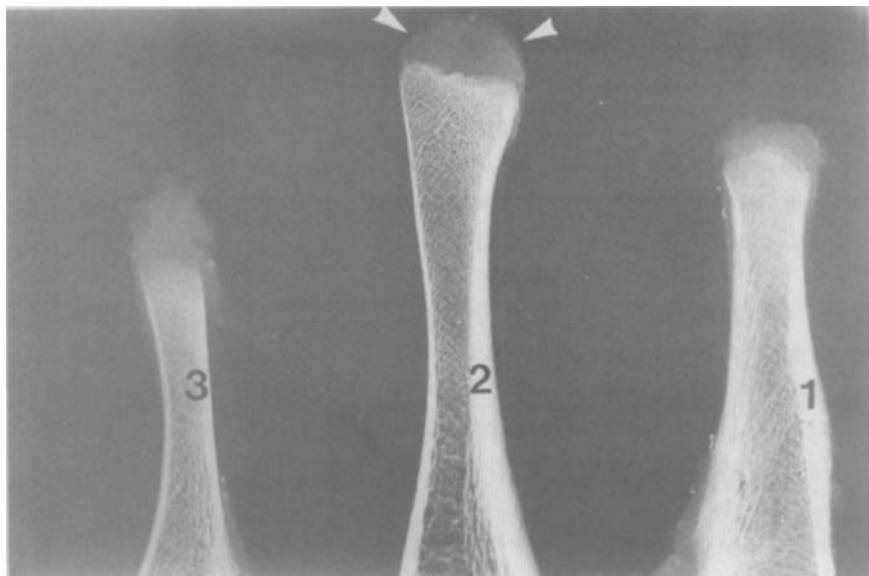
Slab radiographs of vertical sections of bone removed from areas 1, 2 and 3, respectively (see legend Fig. 44). Patient was a sixteen year old male who died by drowning. Note the large cartilagenous cap of iliac crest (arrows). Note also in the radiograph of section 2, the well developed lateral cortical table.
